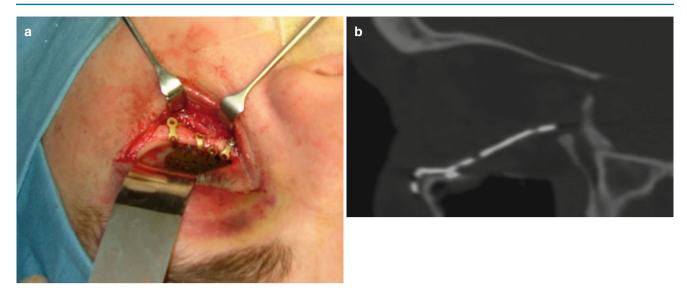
Satisfactory visualisation through a much larger incision confirms accurate repair (a). The CT scan is of a different case (b). Note the built-in curvature of the plate. There is a small amount of soft tissue trapped between it and the posterior ledge, but this was clinically insignificant (there was no diplopia or enophthalmos). A satisfactory result
